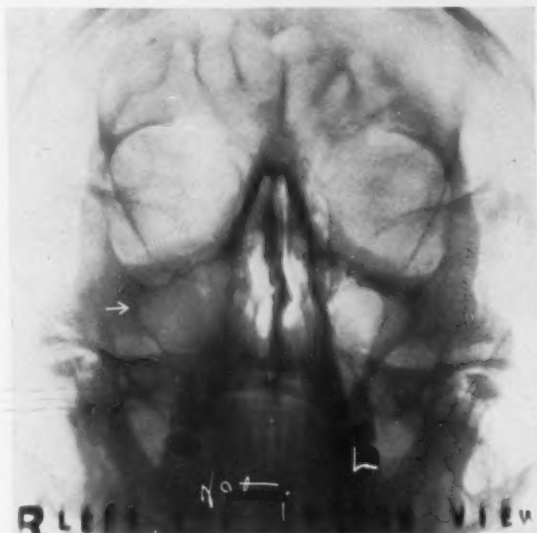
Roentgenogram showing marked cloudiness of the right antrum. Chronic arthritis of three years' duration. Teaspoonful of mucous material removed from antrum. Marked improvement following conservative rhinologic treatment.
